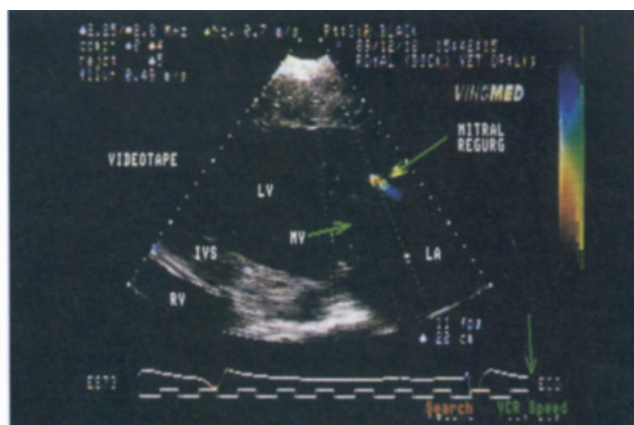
Colour flow study from a left parasternal long-axis apical view. A small blue aliased signal is shown on the left atrial side of the mitral valve. This colour signal followed the large closure pattern shown in Figure 9.
